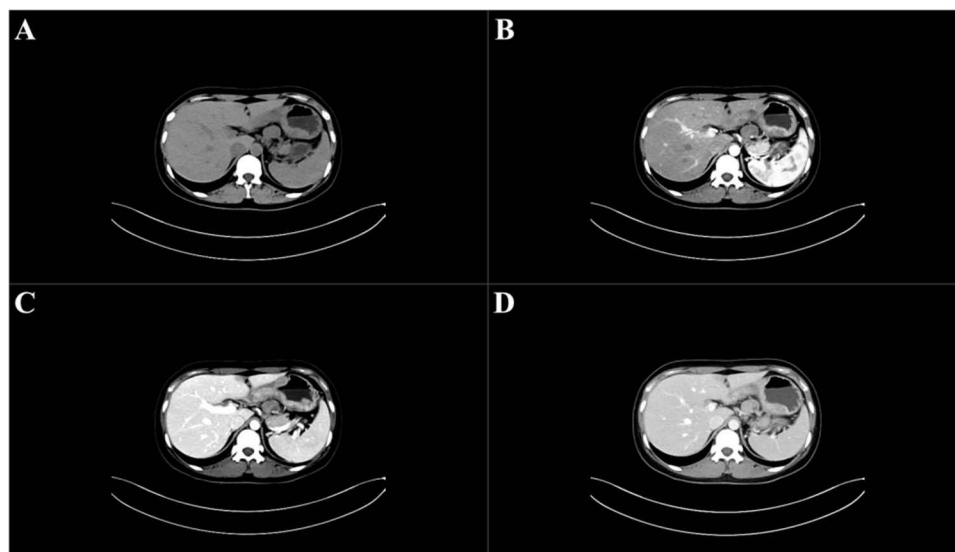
A 64-year-old man with PD-L1-positive. The body of the gastric wall was thickened significantly, the CT values of the lesion on plain scan (A) and in the arterial phase (B), venous phase (C), delayed phase (D) were 53HU, 104HU, 141HU and 120HU, respectively. There were a lot of enlarged lymph nodes around, and ascites and peritoneal metastasis were not exist. EMVI was positive, and the CT stage was cT4N2.
